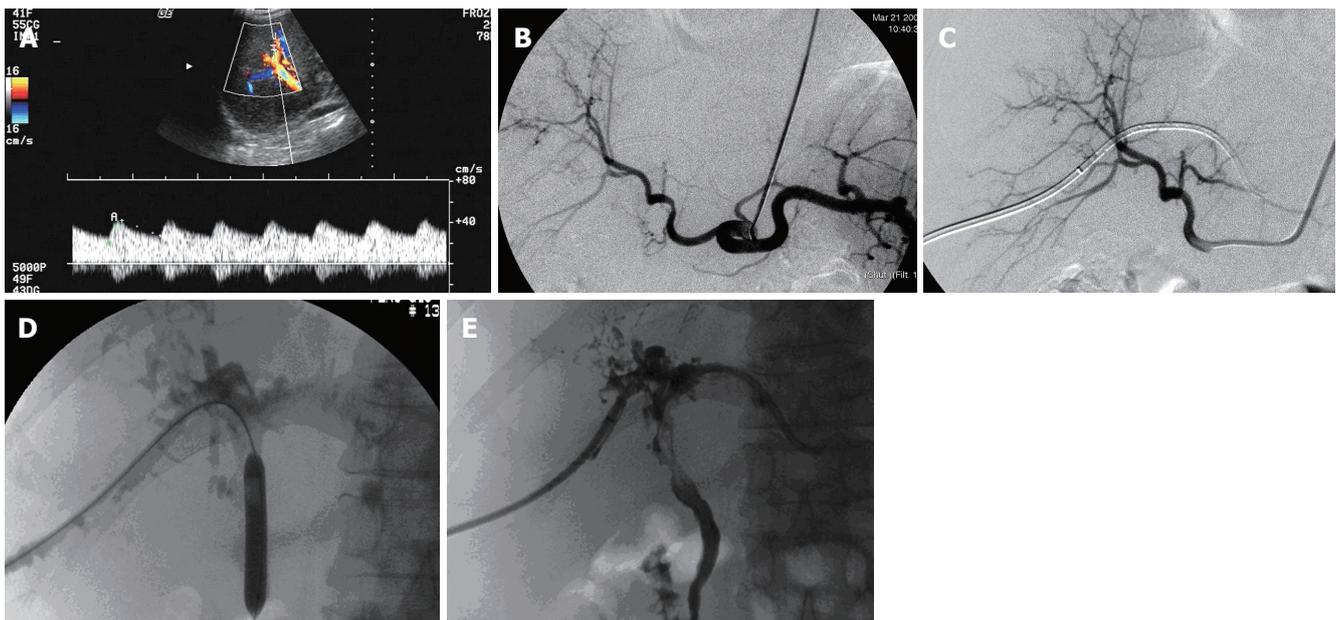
Images pertaining to case 2. HA stoma stricture was diagnosed 3 mo after OLT, no treatment was performed; coronary artery stent placement was performed after 5 mo. Diffuse intra- and extra- hepatic bile duct stricture was apparent 8 mo after OLT. PTBD and balloon dilation therapy were performed. A: Tardus parvus frequency spectrum shown by color Doppler ultrasonography indicating HA stoma stricture; B: HA stoma stricture as indicated by celiac axis angiography; C: Celiac axis angiography revealing HAS disappearance following HA stent placement; D: Treatment of bile duct stricture by percutaneous transhepatic balloon dilation; E: Cholangiography revealed bile duct stiffness, rare branching, and filling defect in the bile duct lumina.
